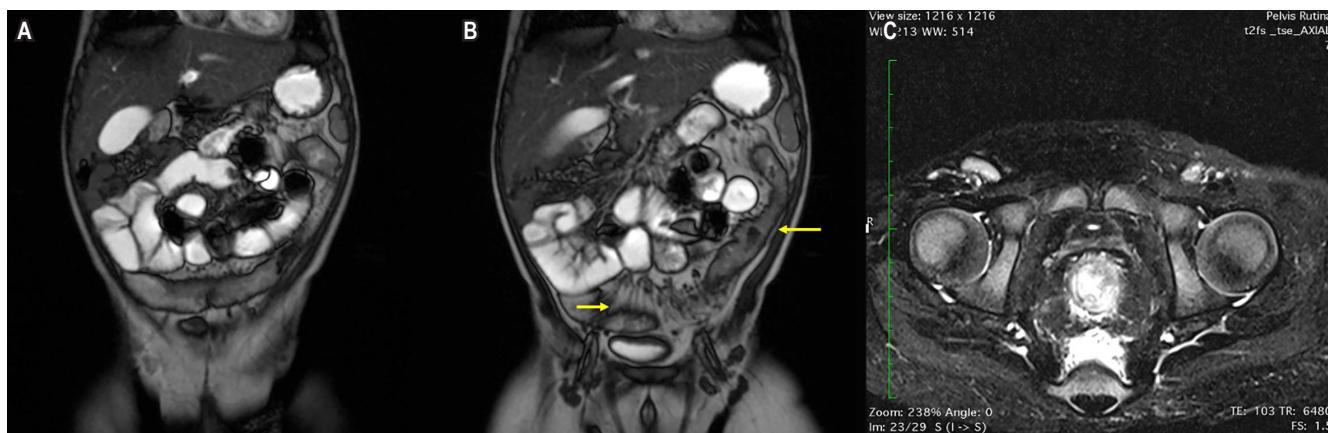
Enterography and pelvic MRI. A. Adequate small bowel distension with normal appearance - no pathological enhancement/wall thickening, stenosis, or dilatation. B. Pathological enhancement and wall thickening throughout the colon (predominantly left/transverse colon) consistent with colitis and vascular engorgement. C. Intersphincteric perianal fistula tract with associated right-quadrant abscess. Images property of the authors.
